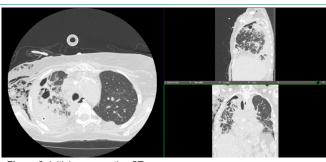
Initial pre-operative CT.
